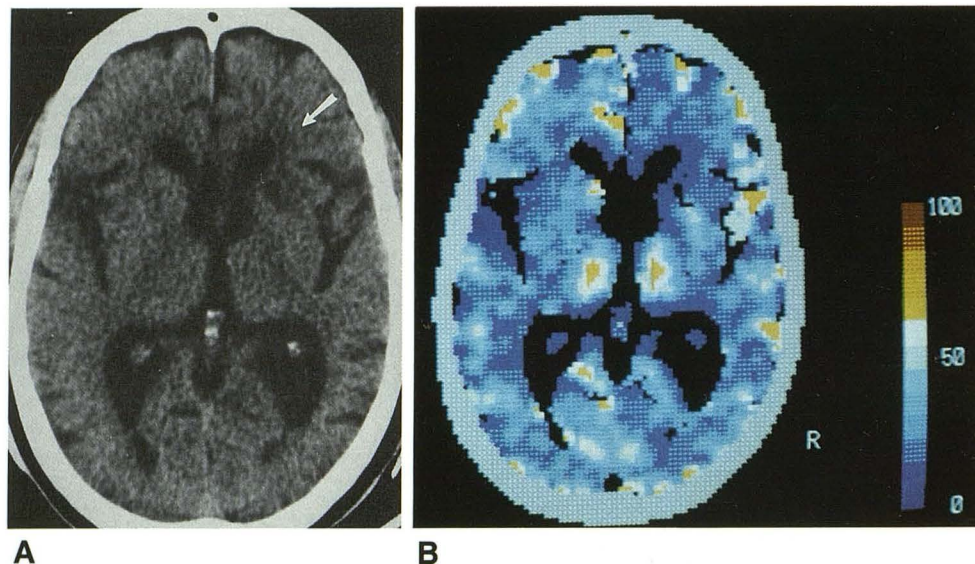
A and B, Plain CT image of the brain (A) and corresponding color-coded map of local cerebral blood flow (B) in an 81-year-old man with multi-infarct dementia. Marked white-matter lesions on MR and CT (arrow) are accompanied by prominent cerebral atrophy. Values for local cerebral blood flow are severely reduced in a patchy manner (cerebral cortex, 31.2 ml/100 g brain/min; subcortex, 44.1; and white matter, 14.3), particularly in frontal and occipital white matter surrounding lateral ventricles. On both images, left hemisphere is to the left and right hemisphere is to the right.
